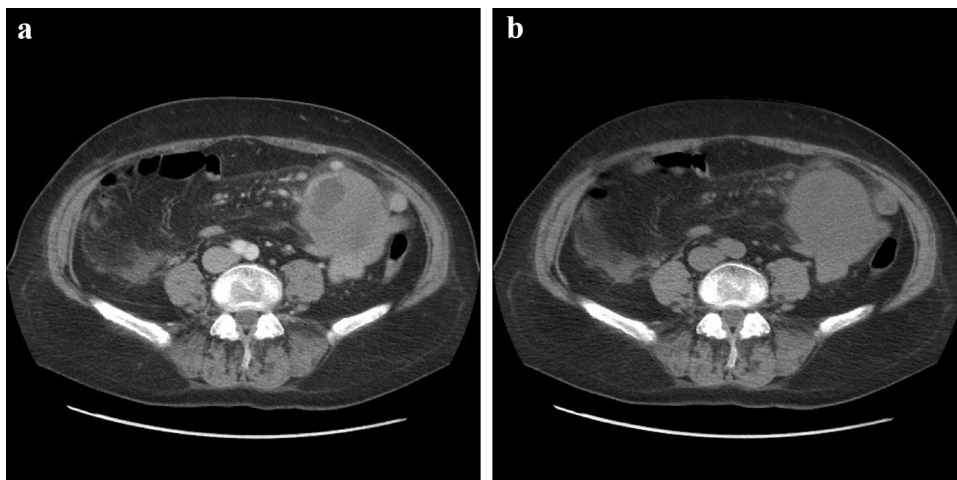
a, b Contrast-enhanced MRI: A venous phase; B late phase. Early enhancement of the mass and persistent enhancement within the mass in the late phase
